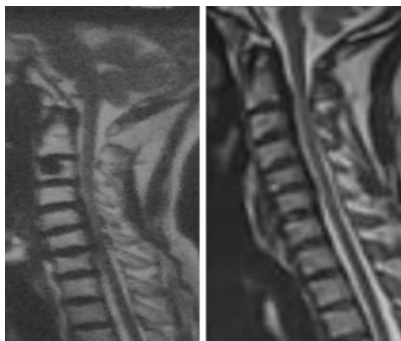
a,b; Showing Pre and post op MRI sagittal scan images of patient without laminectomy.
